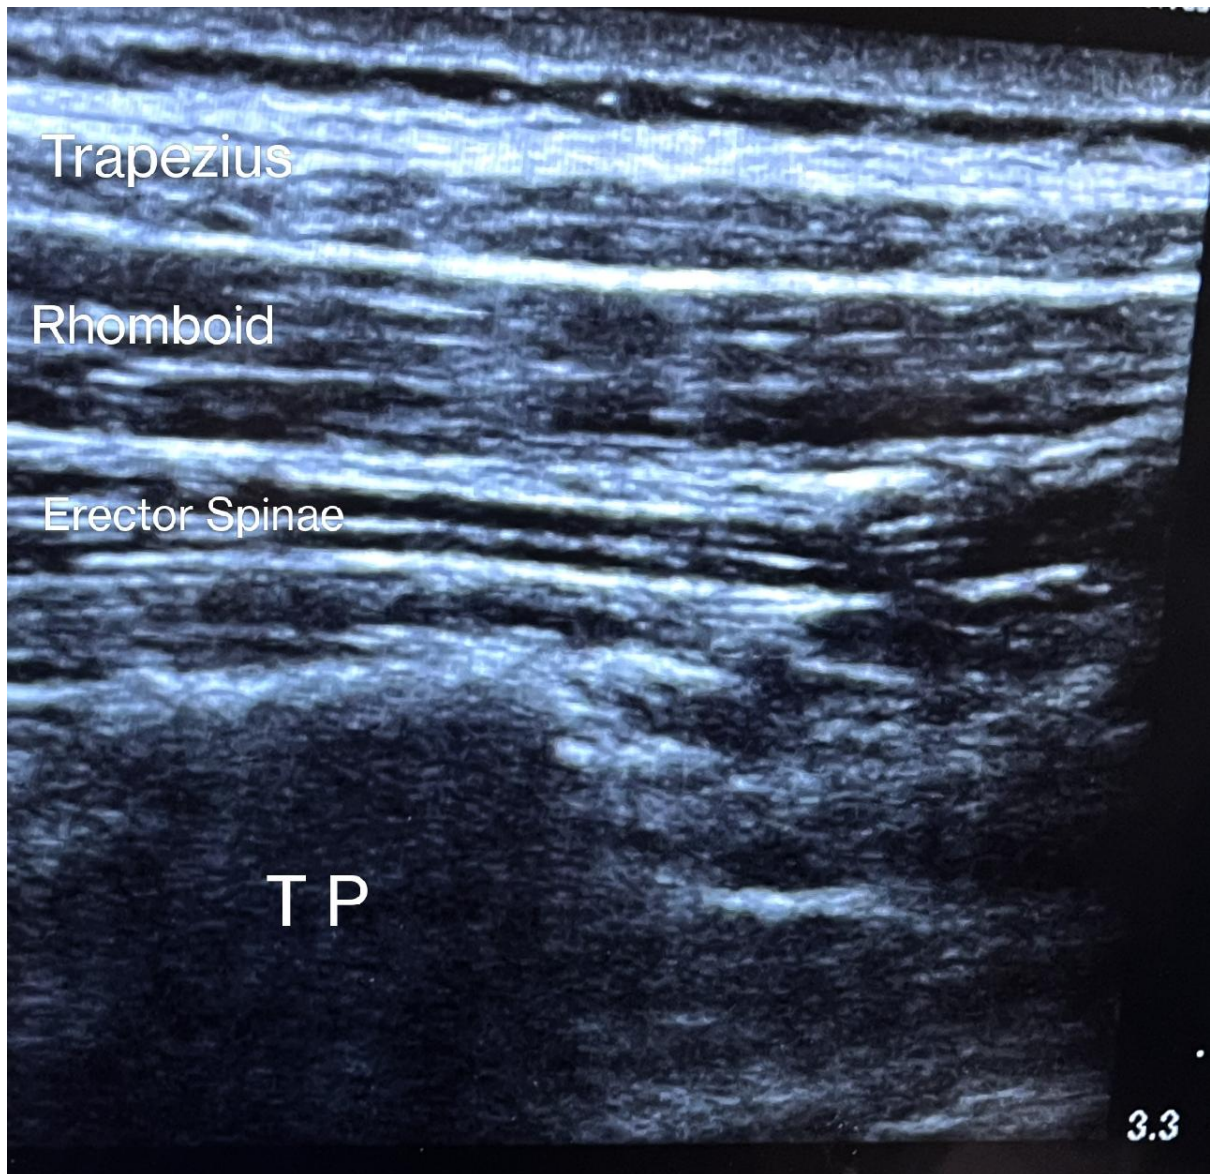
Real time Ultrasound image of ESP Muscles
